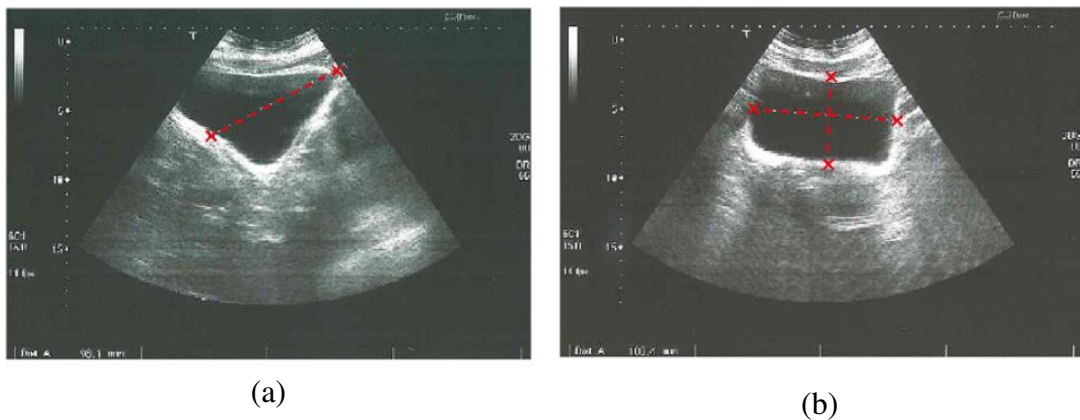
Ultrasonic images for bladder volume measurement: (a) side of the bladder (b) height and width of the bladder
